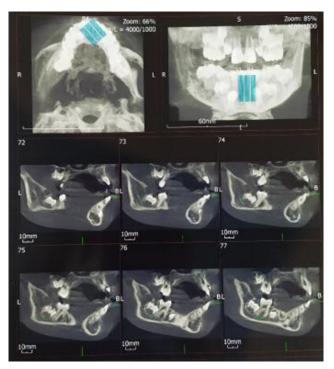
CBCT giving impression of Malignancy of right mandible alveolus 45, ramus, condylar region
